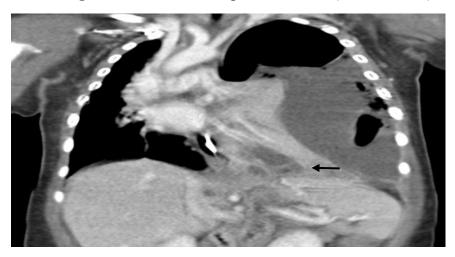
CT Chest (coronal view) showing left extensive empyema (black arrow) with mediastinal shift to the right side.
